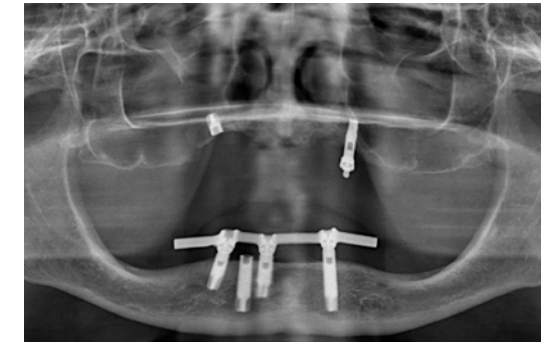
Orthopantomogram: extensive sinus pneumatization.
